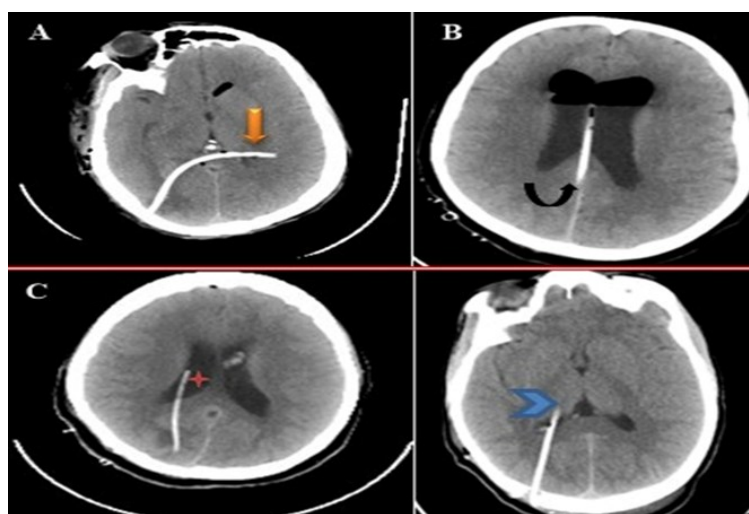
Axial computed tomographic scans showing accuracy of external ventricular catheter tip location: (A) Contralateral parenchyma (orange block arrow). (B) Interhemispheric fissure (curved black arrow) (C) Ipsilateral ventricle (red star) (D) Ipsilateral thalamus (chevron).
